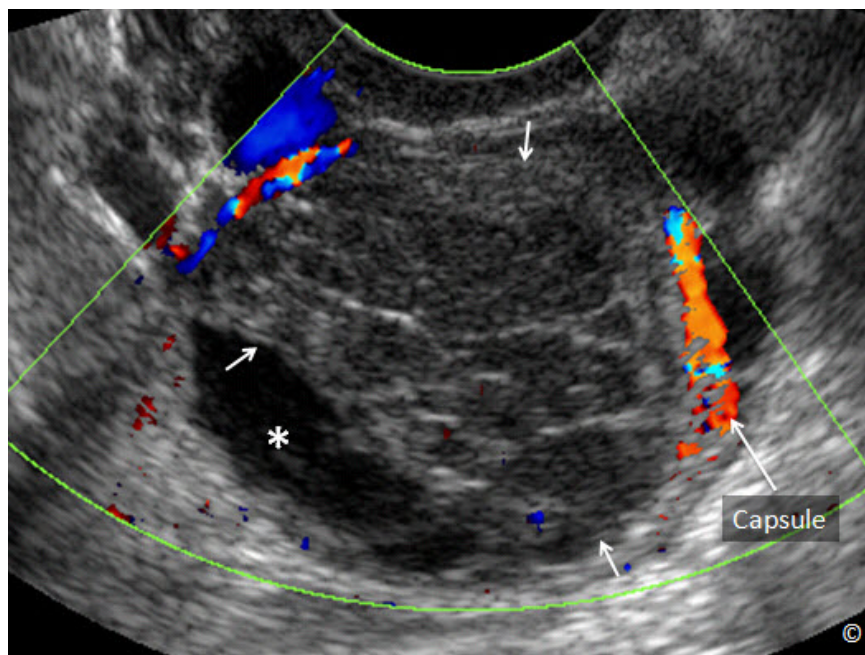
Transvaginal ultrasound with color Doppler of the hemorrhagic cyst in figure 12.11. Note the retraction of the blood clot (asterisk) with the development of a fluid layer. Color Doppler shows vascular flow in the capsule (labeled) but none within the blood clot (arrows).
